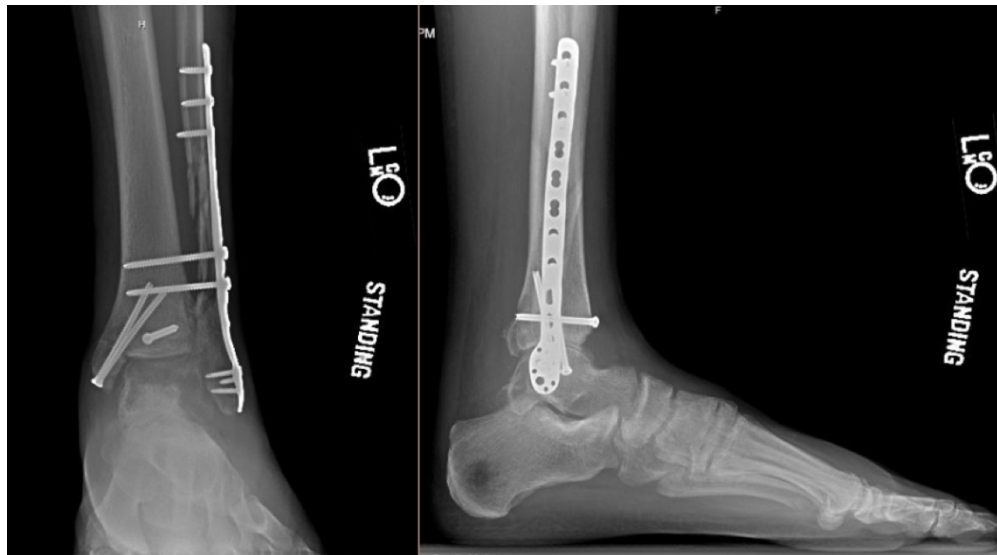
Weight bearing AP and lateral radiographs of the left ankle 3 months following internal fixation. Fibula fracture stabilized with bridge plating and syndesmotic screws. Medial and posterior malleoli anatomically reduced and fixed using lag screw technique.
